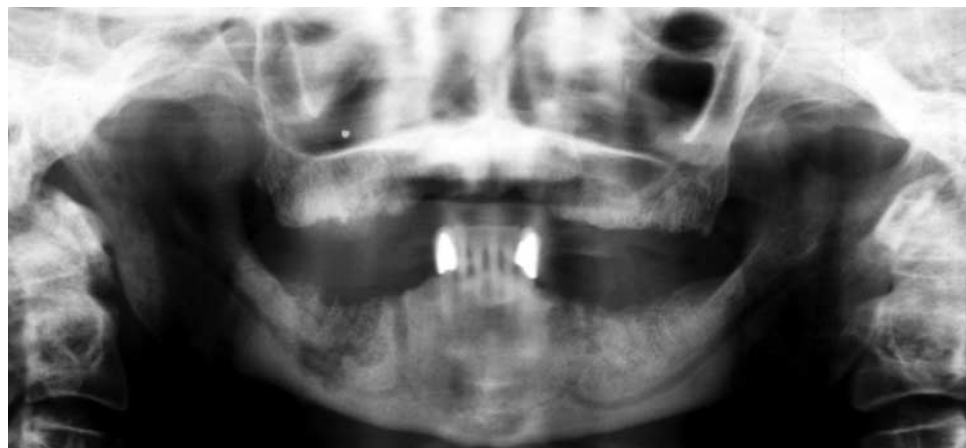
Panoramic radiograph demonstrating osteolysis with typical mottled pattern of bone in the mandible of a patient with a history of having received zoledronic acid therapy. The extension of the osteolysis into the inferior alveolar canal on the right side correlated with mandibular nerve paresthesia.
